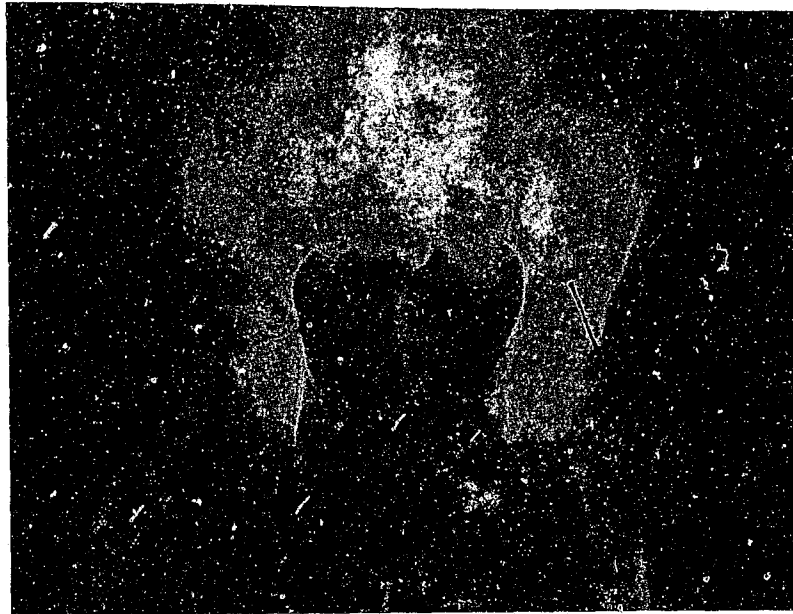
Radiograph showing Trethowan's (Klein's) line: A line drawn along the superior aspect of the femoral neck should pass through the head of the femur, as in the left hip. The right hip shows the presentation in a case of SCFE.
